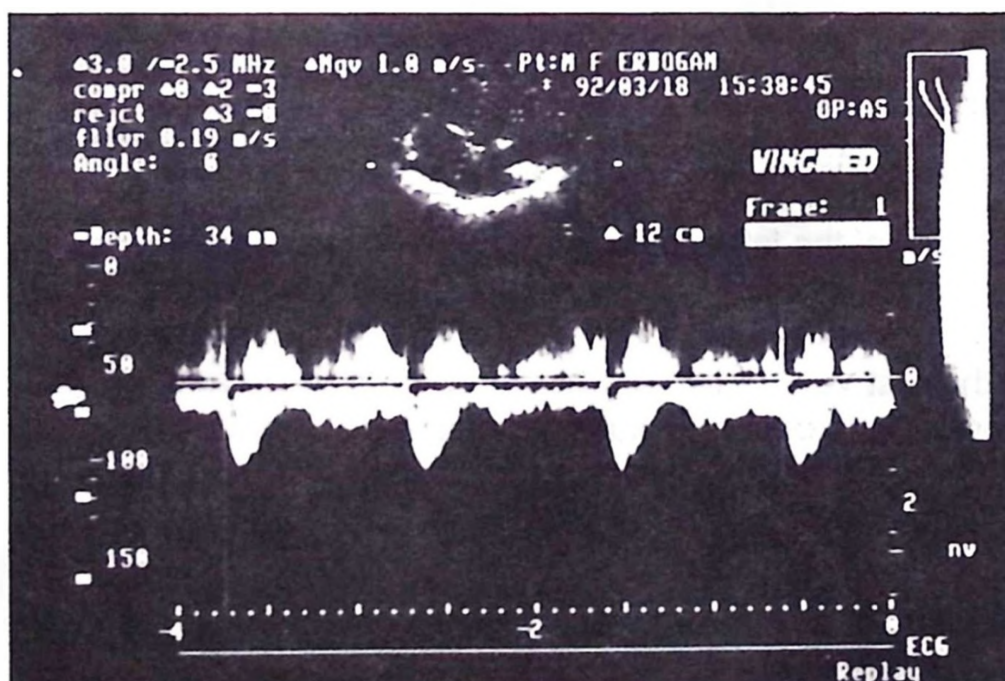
Sampling by HPRF Doppler in the midmuscular septum showing the presence of continuous flow (Case 1).
